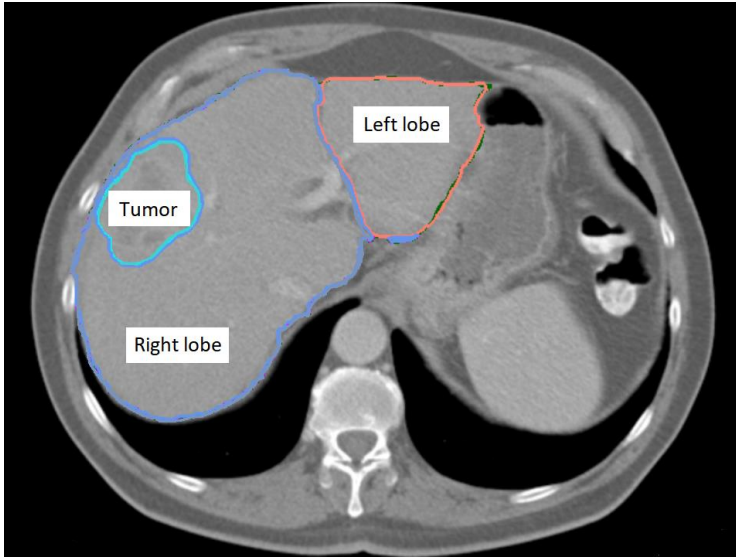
Anatomical contours on contrast-enhanced CT of right lobe (blue), tumor (green) and left lobe (tan).
